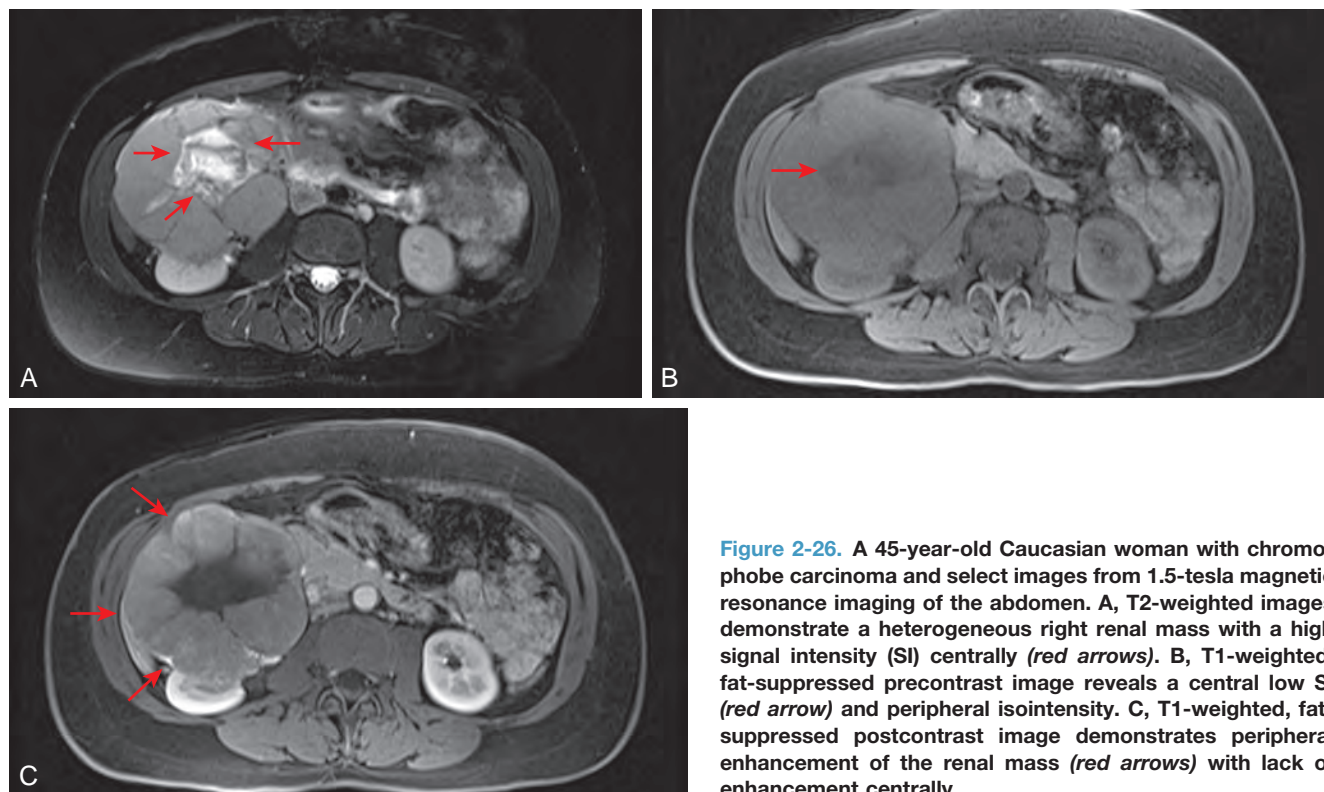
A 45-year-old Caucasian woman with chromophobe carcinoma and select images from 1.5-tesla magnetic resonance imaging of the abdomen. A, T2-weighted images demonstrate a heterogeneous right renal mass with a high signal intensity (SI) centrally (red arrows). B, T1-weighted, fat-suppressed precontrast image reveals a central low SI (red arrow) and peripheral isointensity. C, T1-weighted, fat-suppressed postcontrast image demonstrates peripheral enhancement of the renal mass (red arrows) with lack of enhancement centrally.
